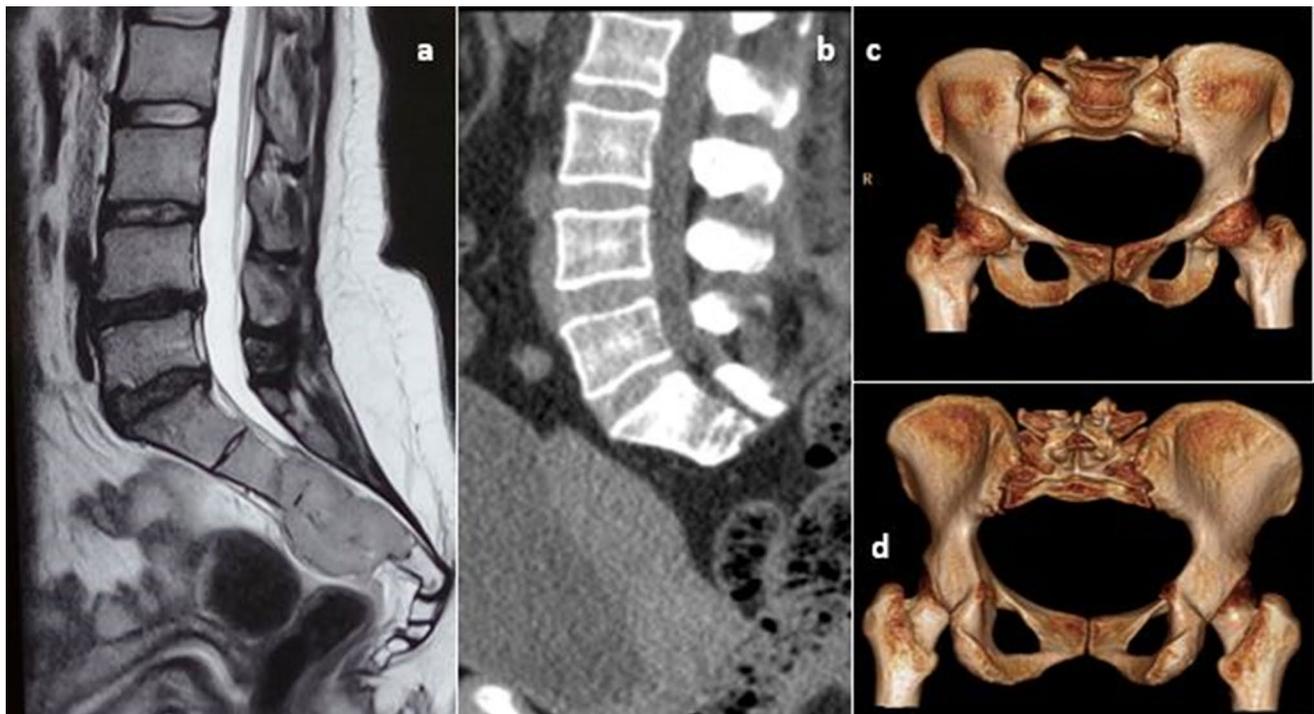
a Preoperative T2-weighted MRI showing giant-cell tumour extending from S2-S4. b Post-operative sagittal CT following *en bloc* resection of the tumour. c, d CT with 3D reconstruction at 30 months follow-up
